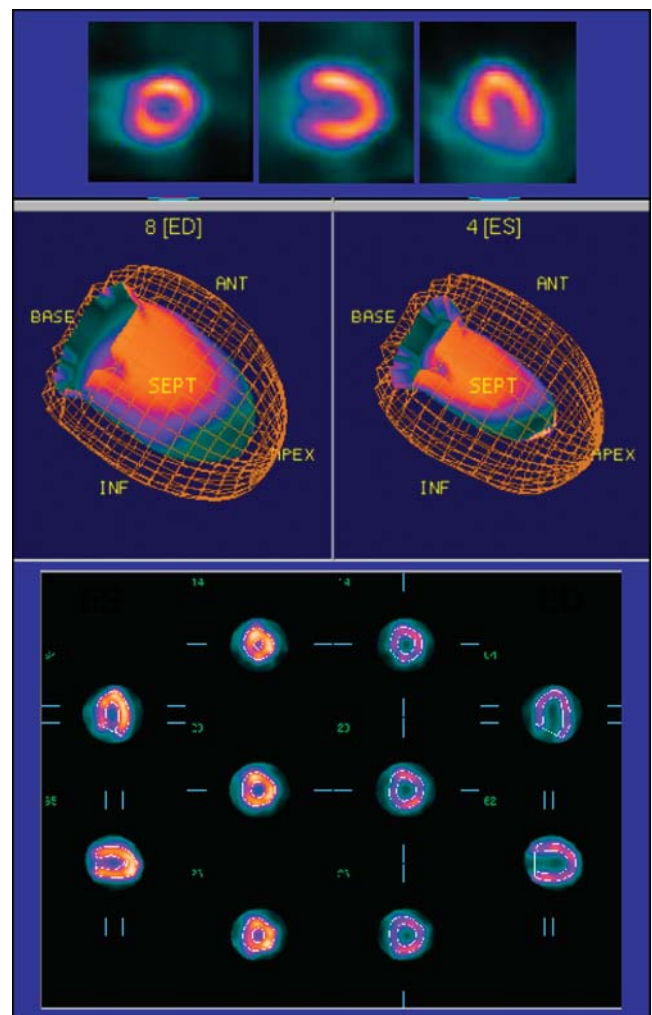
Clinical feasibility study acquired with the D-SPECT cardiac system, which provides a 10-fold increase in sensitivity and a 2-fold increase in resolution over most currently used systems.
